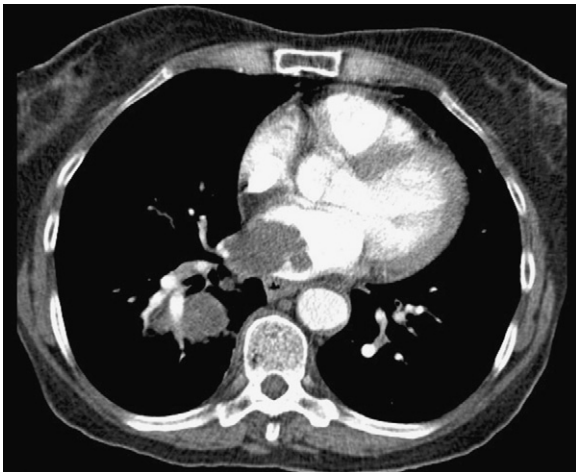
Chest computed tomographic scan: lung tumour arising from the right lower lobe bronchus and extending into the left atrium via the pulmonary vein, in addition to subcarinal mediastinal adenopathy.
